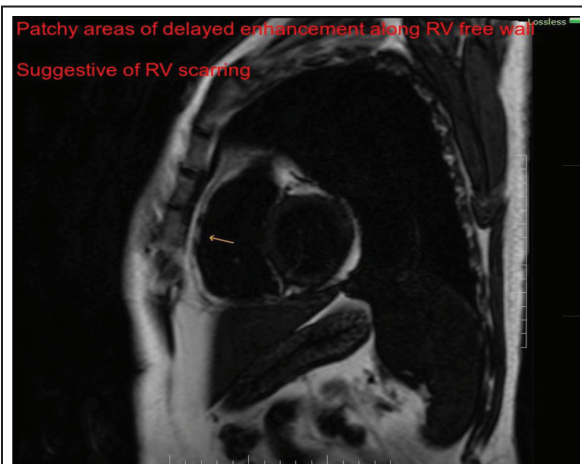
MRI suggestive of RV scarring.
